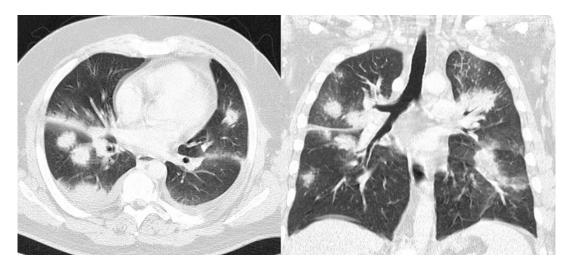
Angioinvasive aspergillosis in a 35-year-old man with acute lymphatic leukemia. CT scan shows bilateral peribronchovascular nodular lung lesions
